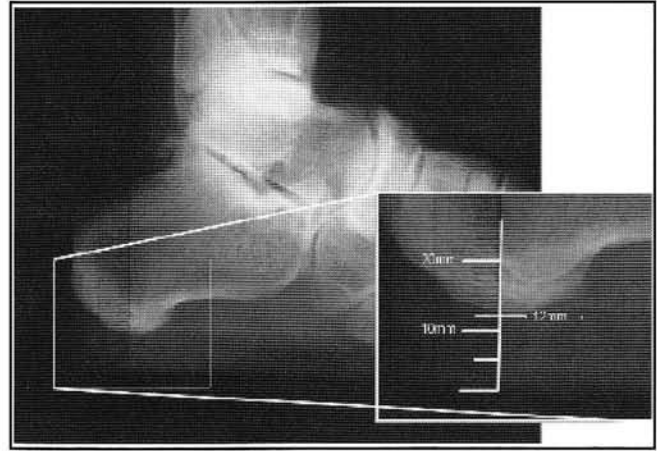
Standard weight-bearing lateral radiograph of the foot depicting a heel pad thickness of 12mm.
